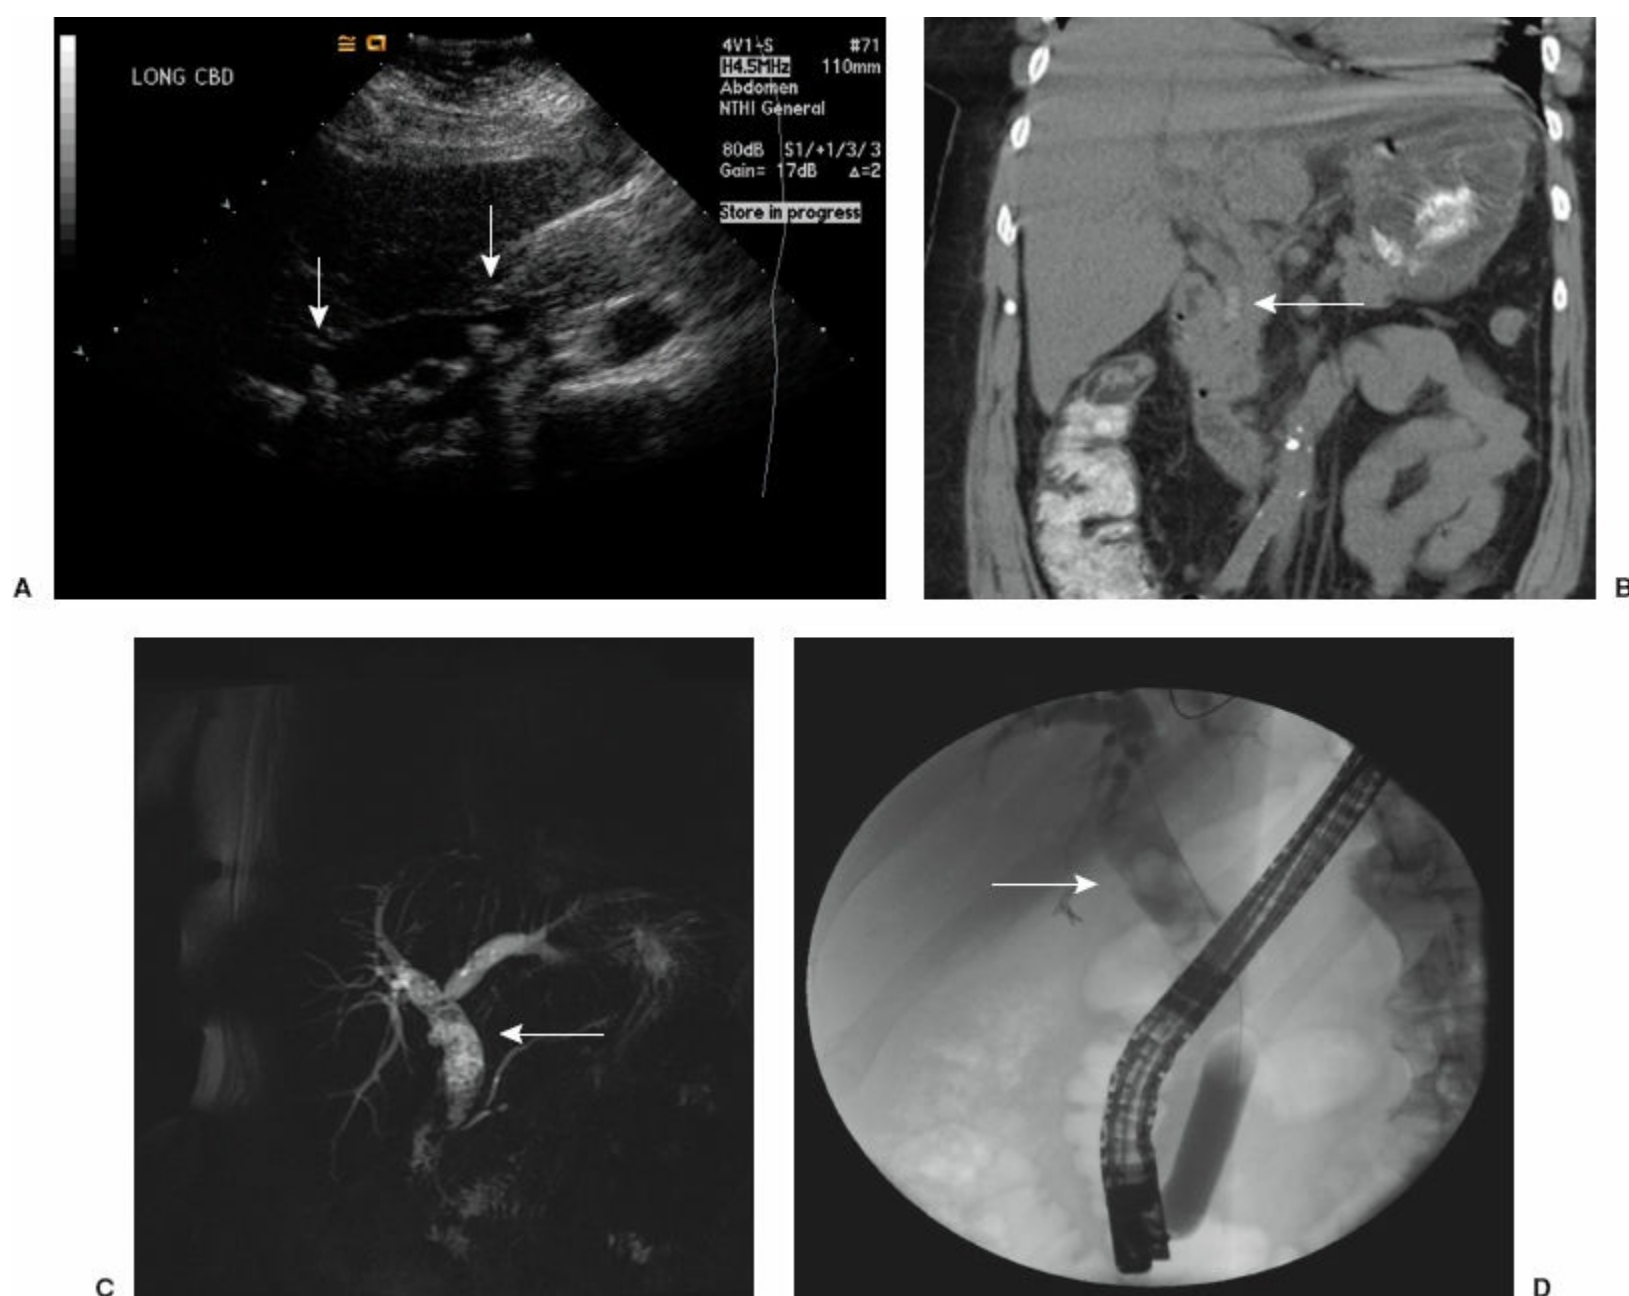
CBD stones are identified (*white arrow*) on ultrasonography (A), computed tomography (B), MRCP (C), and ERCP (D).
